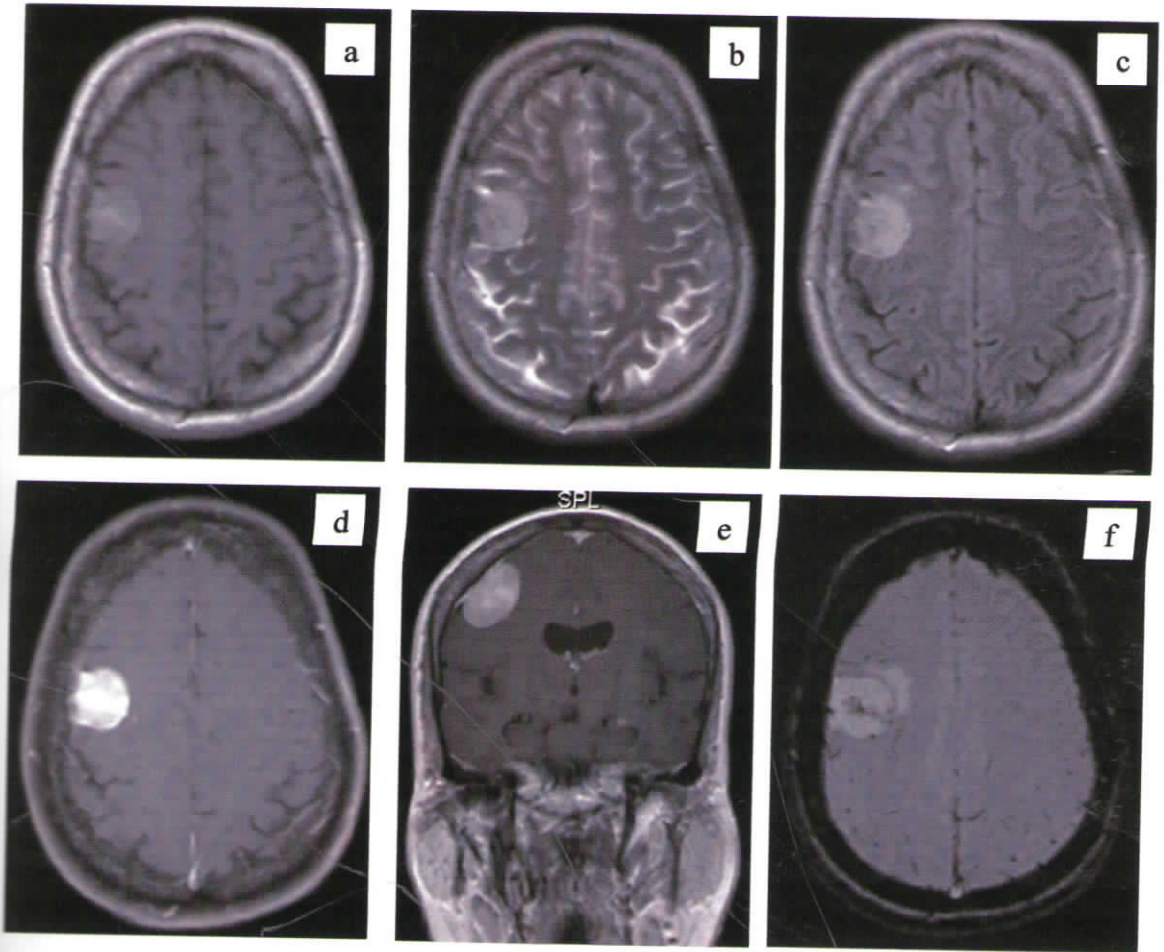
Right frontal mid-convexity meningioma: Isointense on T1 (a), hyperintense on T2 (b) and FLAIR (c), homogenously enhancing on contrast (d), coronal imaging (e) showing dural tail, susceptibility artifacts on SWI (f)
